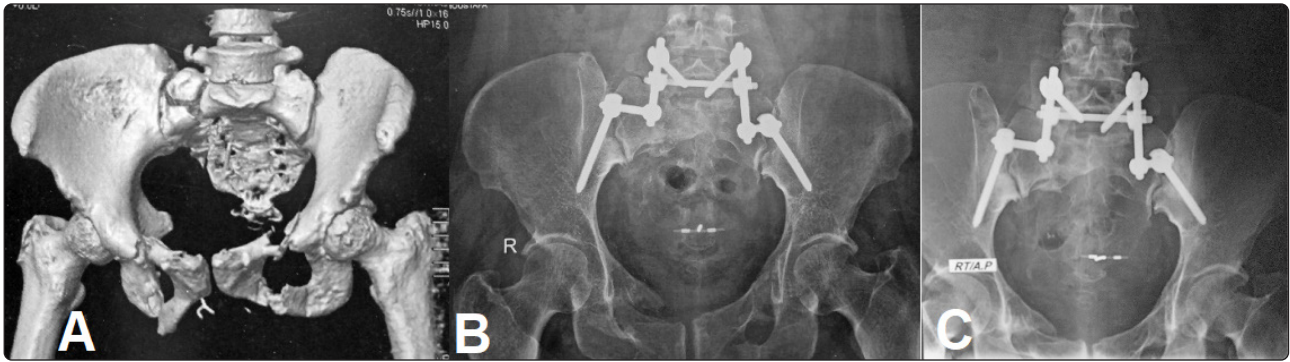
Images of (patient No. 4) 45 years old female patient presented after a fall from height with AO Spine type C 1 sacral fracture, (A) 3D CT-Scan depicting type C1 sacral fracture associated with bilateral pubic rami fractures, (B) 6 months and (C) 12 months postoperative AP view plain radiographs showing lumbopelvic fixation with stable construct with fracture healing.
